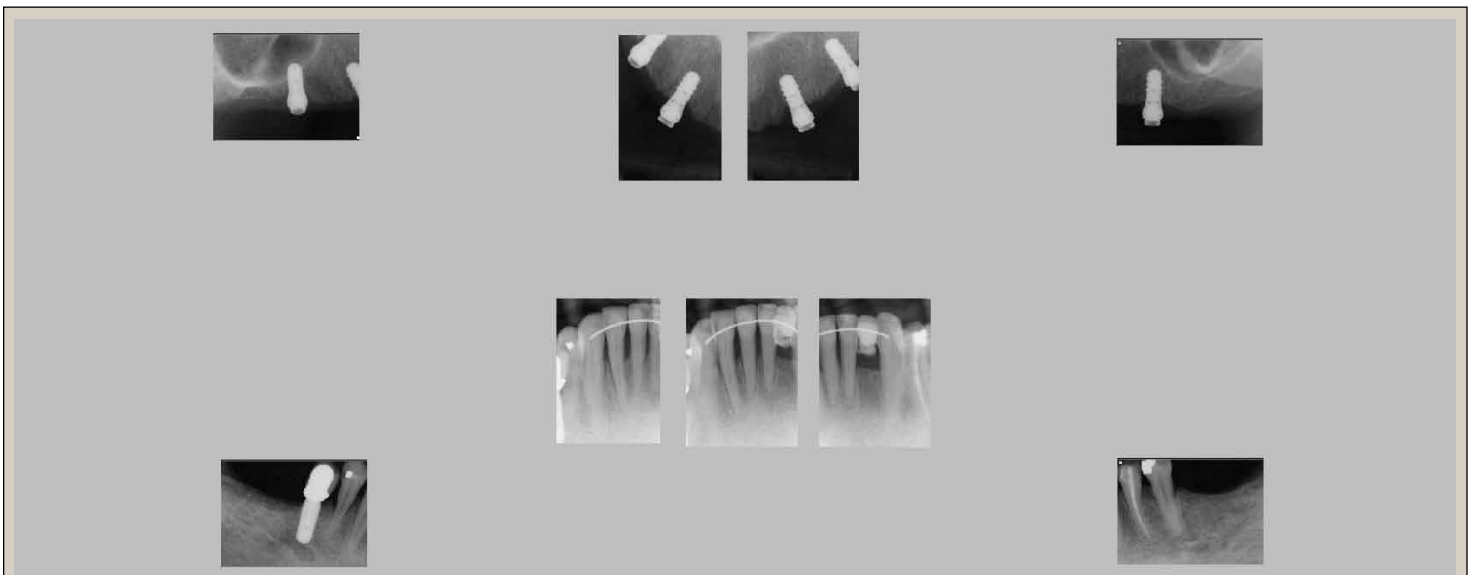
Full-mouth radiographs after treatment.
